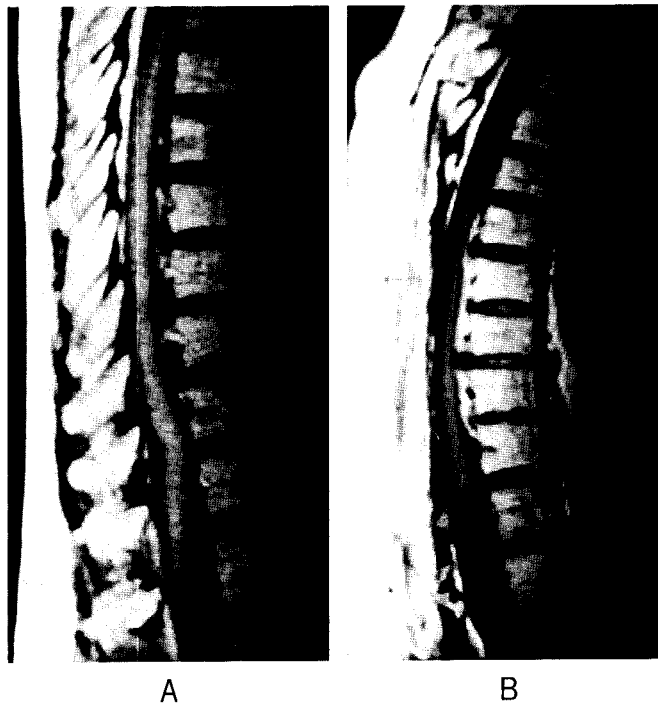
Case No. 9. A 56-year-old woman with OPLL at T7-T11 and OYL at T11-T12. A: Before surgery (T1 weighted MRI), B: After surgery (T1 weighted MRI).
